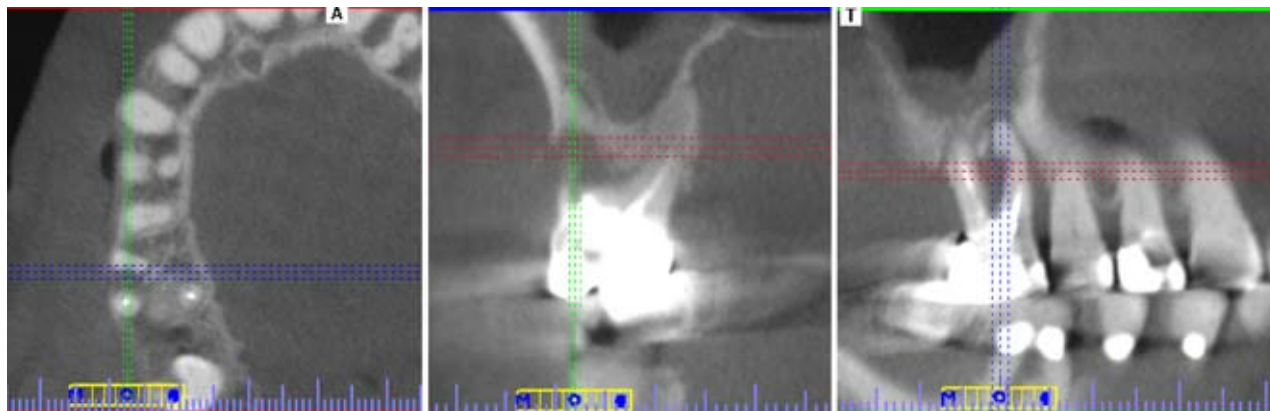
Superimposition-free axial, coronal and sagittal CBCT-views (tooth 16) with an apical periodontitis and loss of buccal lamella and inter-radicular bone
